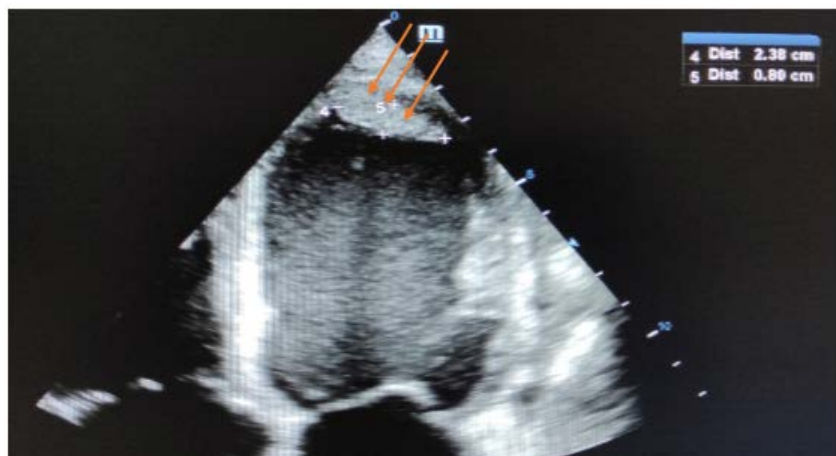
Transthoracic echocardiography in apical window 4 cavities showing an apical intraventricular left thrombus (red arrows) of 23.8mm X 8mm in a patient with peripartum cardiomyopathy in Parakou in 2022.
